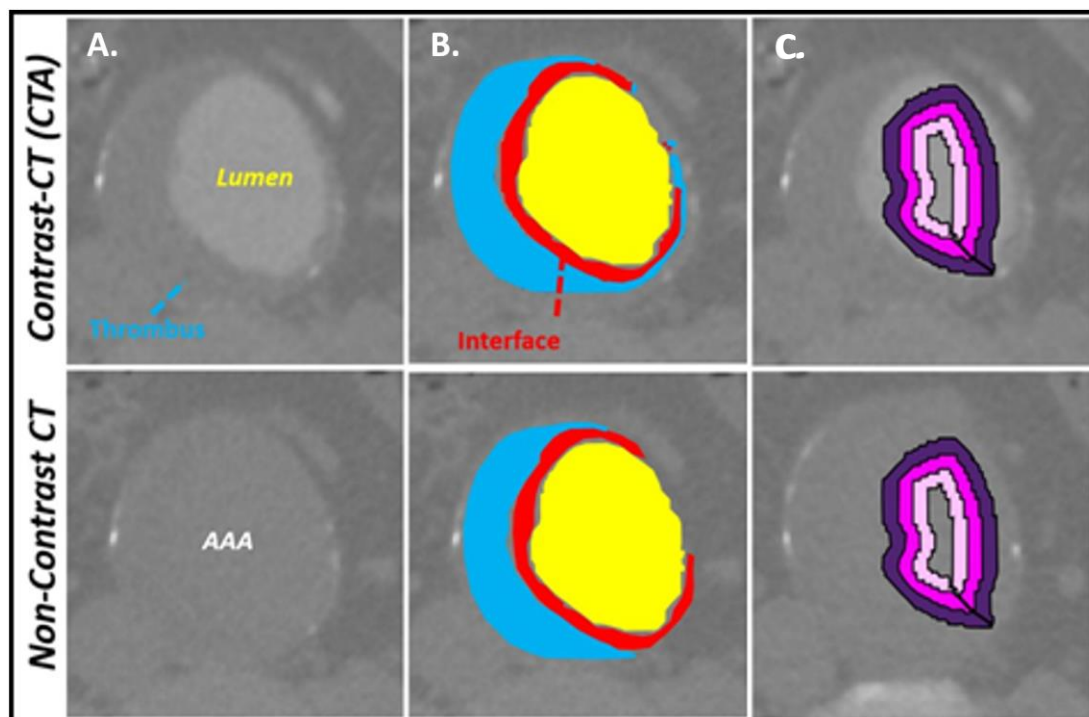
Axial slices from both the Contrast and Non-contrast CT scans. Demarcated regions display the thrombus (blue), lumen (yellow) and the interface between the regions (red). Hounsfield unit sampling of the lumen, interface and thrombus was performed within each region. Concentric sampling within the lumen as demarcated by the pink, magenta and purple, was used as negative control for this experiment. Hounsfield unit sampling within the lumen was hypothesized to have minimal difference compared against that of the interface and thrombus¹¹.
